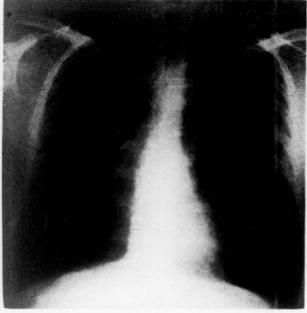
Case II. Roentgenogram of the chest taken on April 20, 1957, showing signs of emphysema, depressed diaphragms, and prominent pulmonary artery shadows at the hila. The lung fields are unusually clear.
